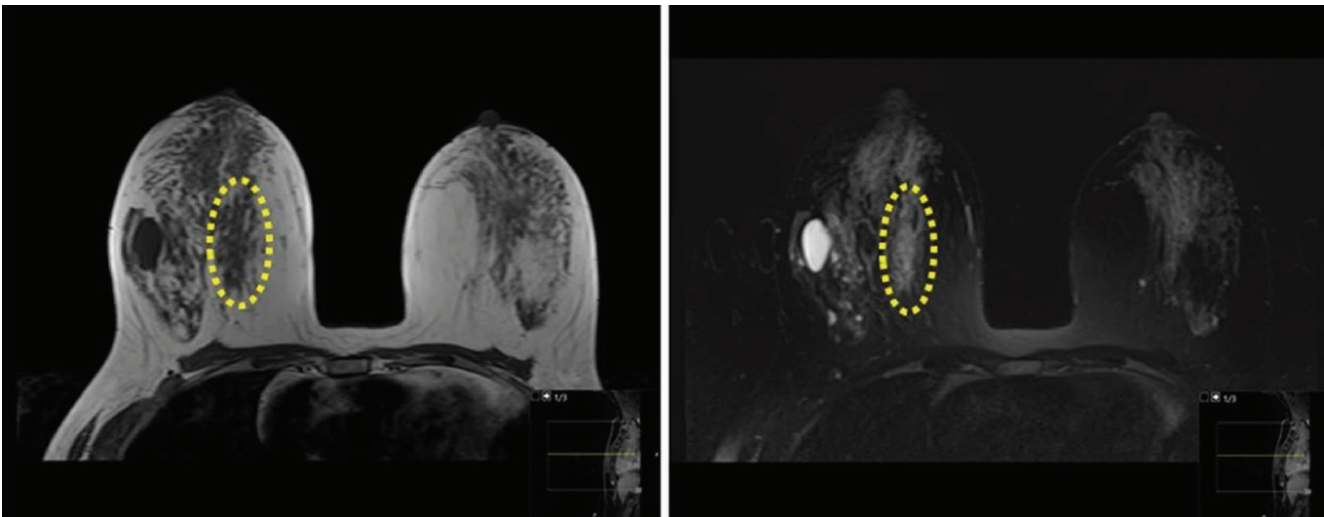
T1W and T2W MRI ; the circle indicates asymmetric tissue in the upper inner quadrant of the right breast that was isointense with breast tissue on T1W MRI and slightly hyperintense on T2W MR image
